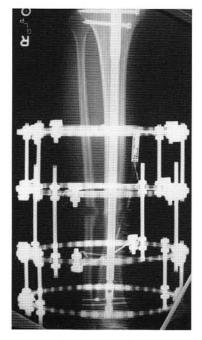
Postoperative AP radiograph the day of surgery.
